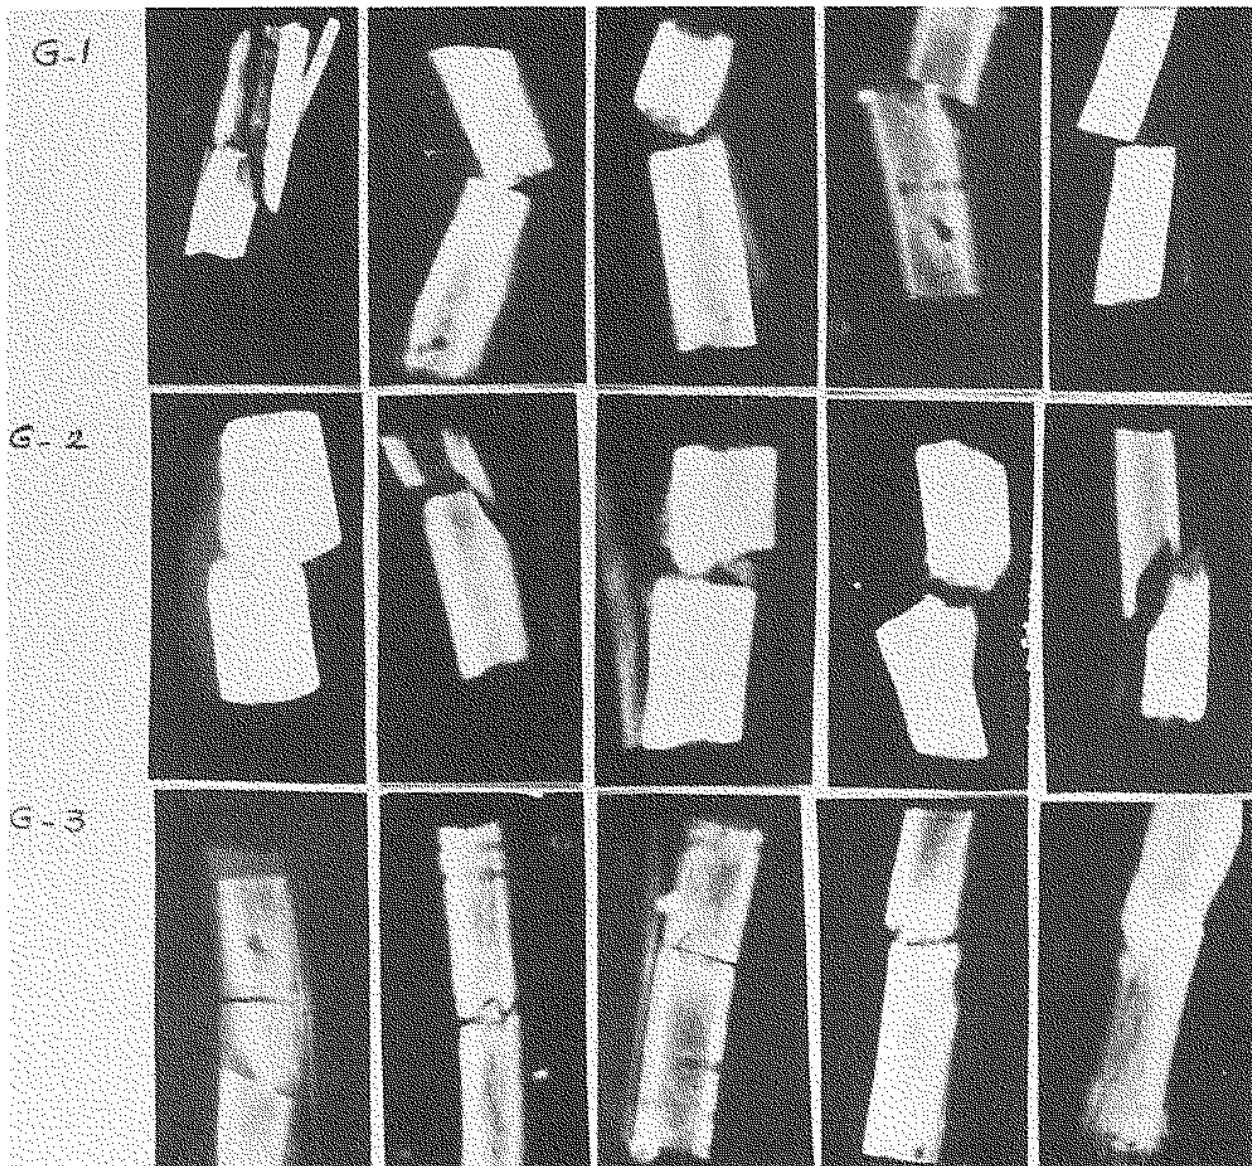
X-rays for evaluation of fragment opposition and periosteal callus formation. G-1 & 2 showed displacement and angulation with increased periosteal callus. G-3 showed improvement of medullary callus.
